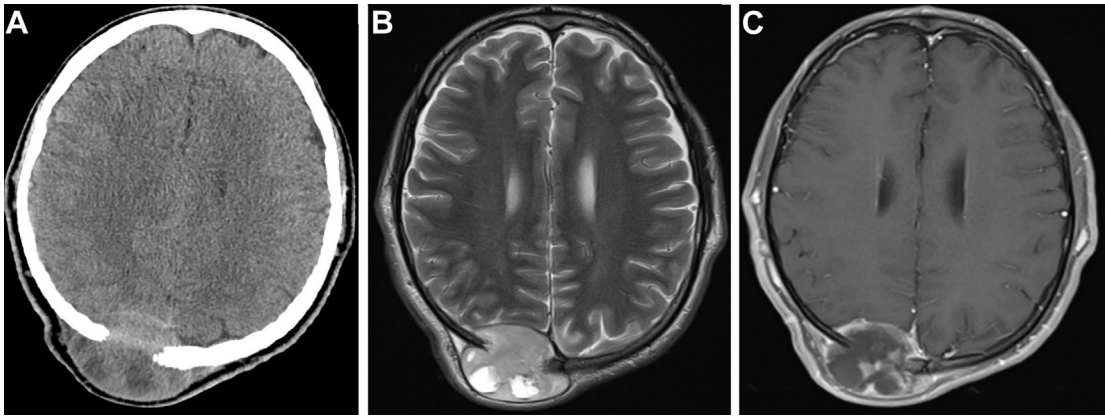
Rapidly growing right parietal scalp mass in a 28-year-old man with NF1. (A) Axial contrast-enhanced CT, (B) axial T2WI, and (C) postcontrast T1WI show heterogeneously enhancing mass with cysts and necrosis. There is also calvarial destruction by the mass.
